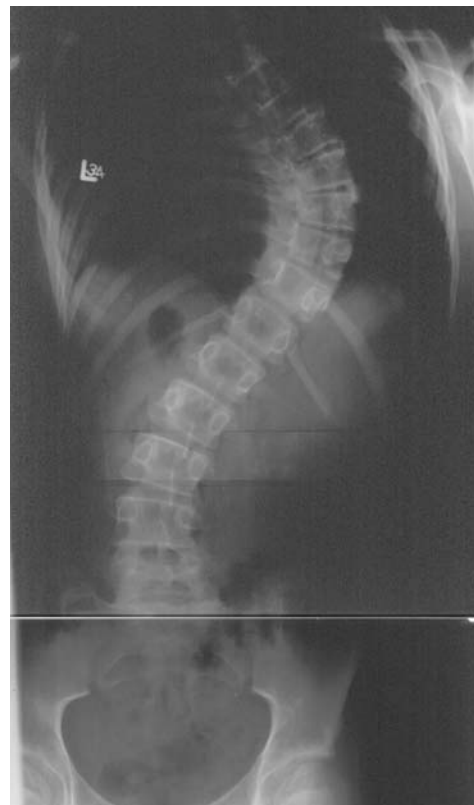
Posteroanterior radiograph of the spine in a patient with a thoracic spinal curve. Right thoracic curve, T6-11 (most tilted vertebrae above apex of curve T6, most tilted vertebrae below apex of curve T11). The degree of curvature is 65.
